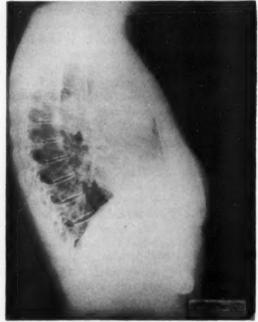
Left lateral x-ray of chest, showing antero-superior position of mediastinal tumor.
